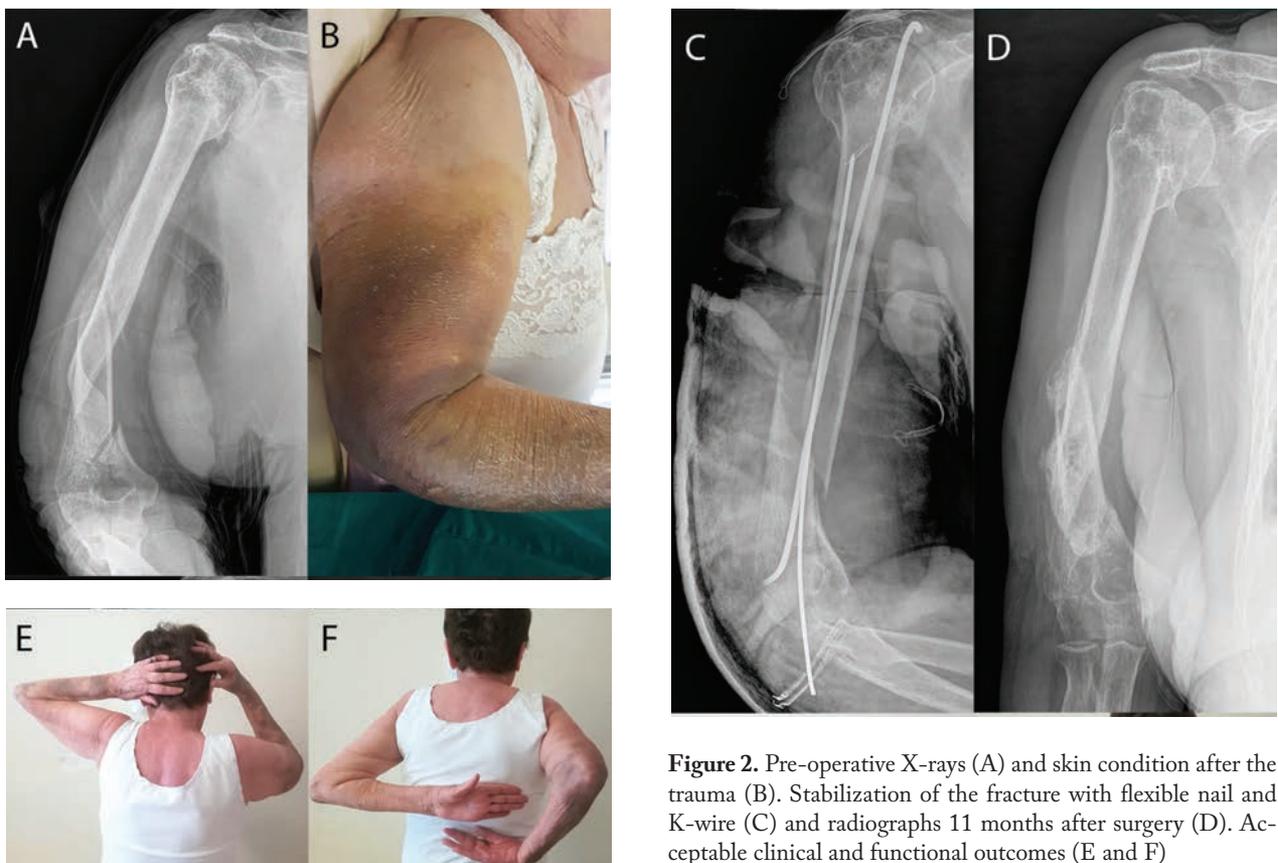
Pre-operative X-rays (A) and skin condition after the trauma (B). Stabilization of the fracture with flexible nail and K-wire (C) and radiographs 11 months after surgery (D). Acceptable clinical and functional outcomes (E and F)
